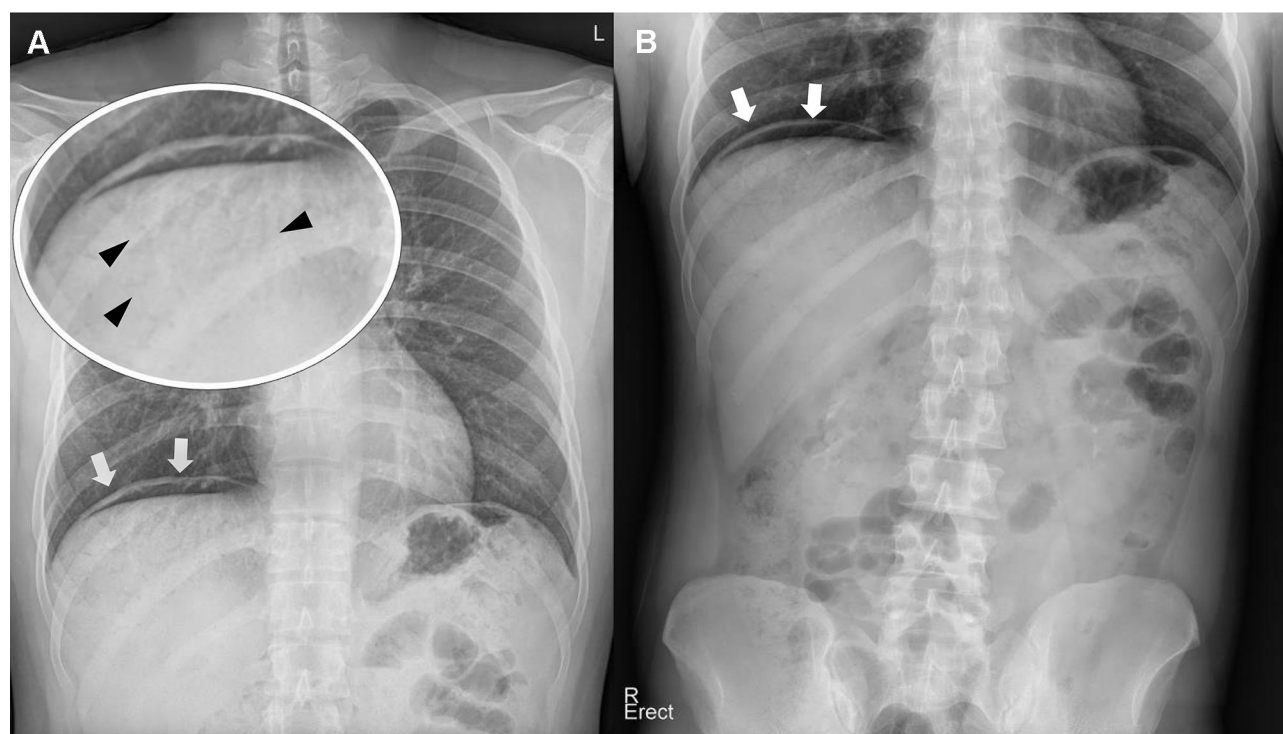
Plain chest (A) and abdominal (B) radiograph showing subphrenic free air (white arrow) and hepatic portal venous gas (arrowhead).
